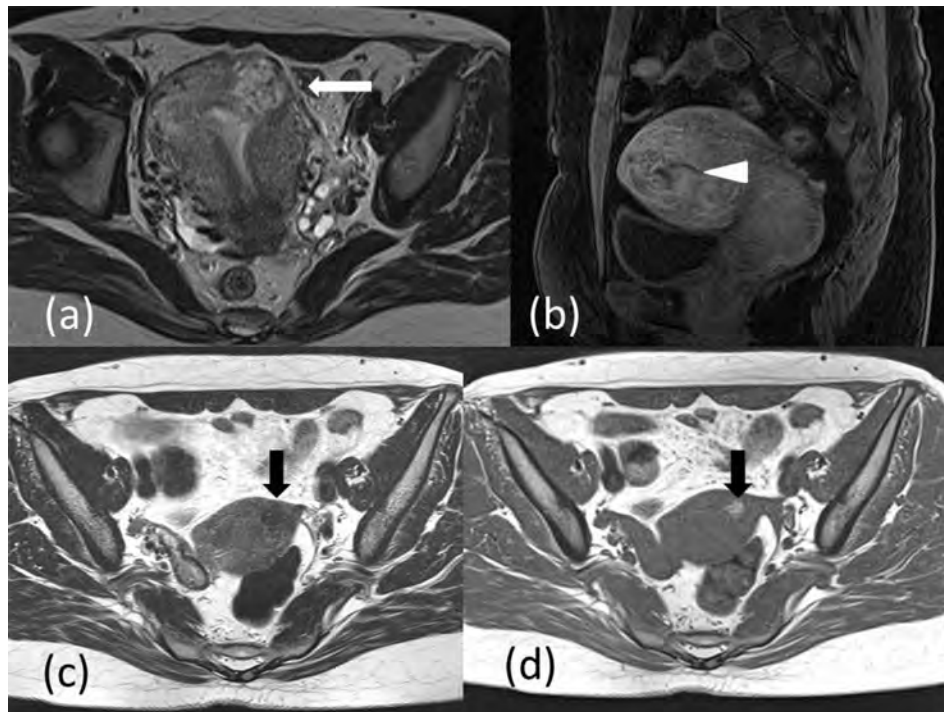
Magnetic resonance images. (a) The uterine tumor (arrow) exhibited a hyperintense signal on axial T2-weighted image at the time of diagnosis as metastatic gestational trophoblastic disease. (b) The prominent tumor with flow void (triangle) on sagittal contrast-enhanced T1-weighted image. (c) The uterine mass (arrow) reduces in size, approximately 1 cm, and could be detected as a hypointense signal on T2-weighted images after 11 cycles of combination chemotherapy. (d) The enhanced region (arrow) on contrast-enhanced T1-weighted image.
